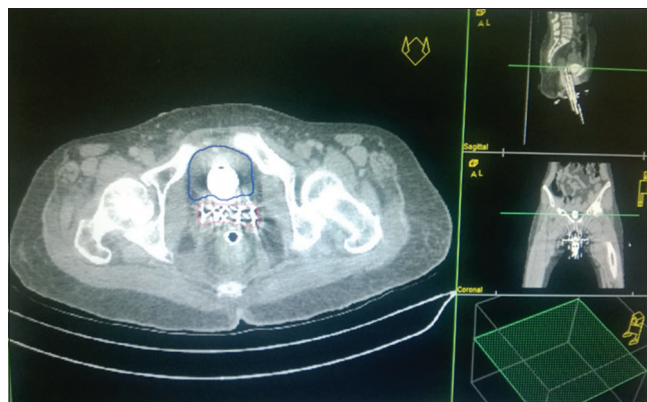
Cross sectional image of CT scan along with reconstructed images with contouring of target and organ at risk
